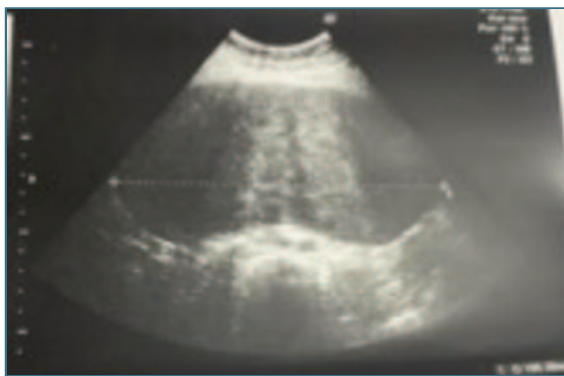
Ultrasound image of the fibroid at diagnosis.
